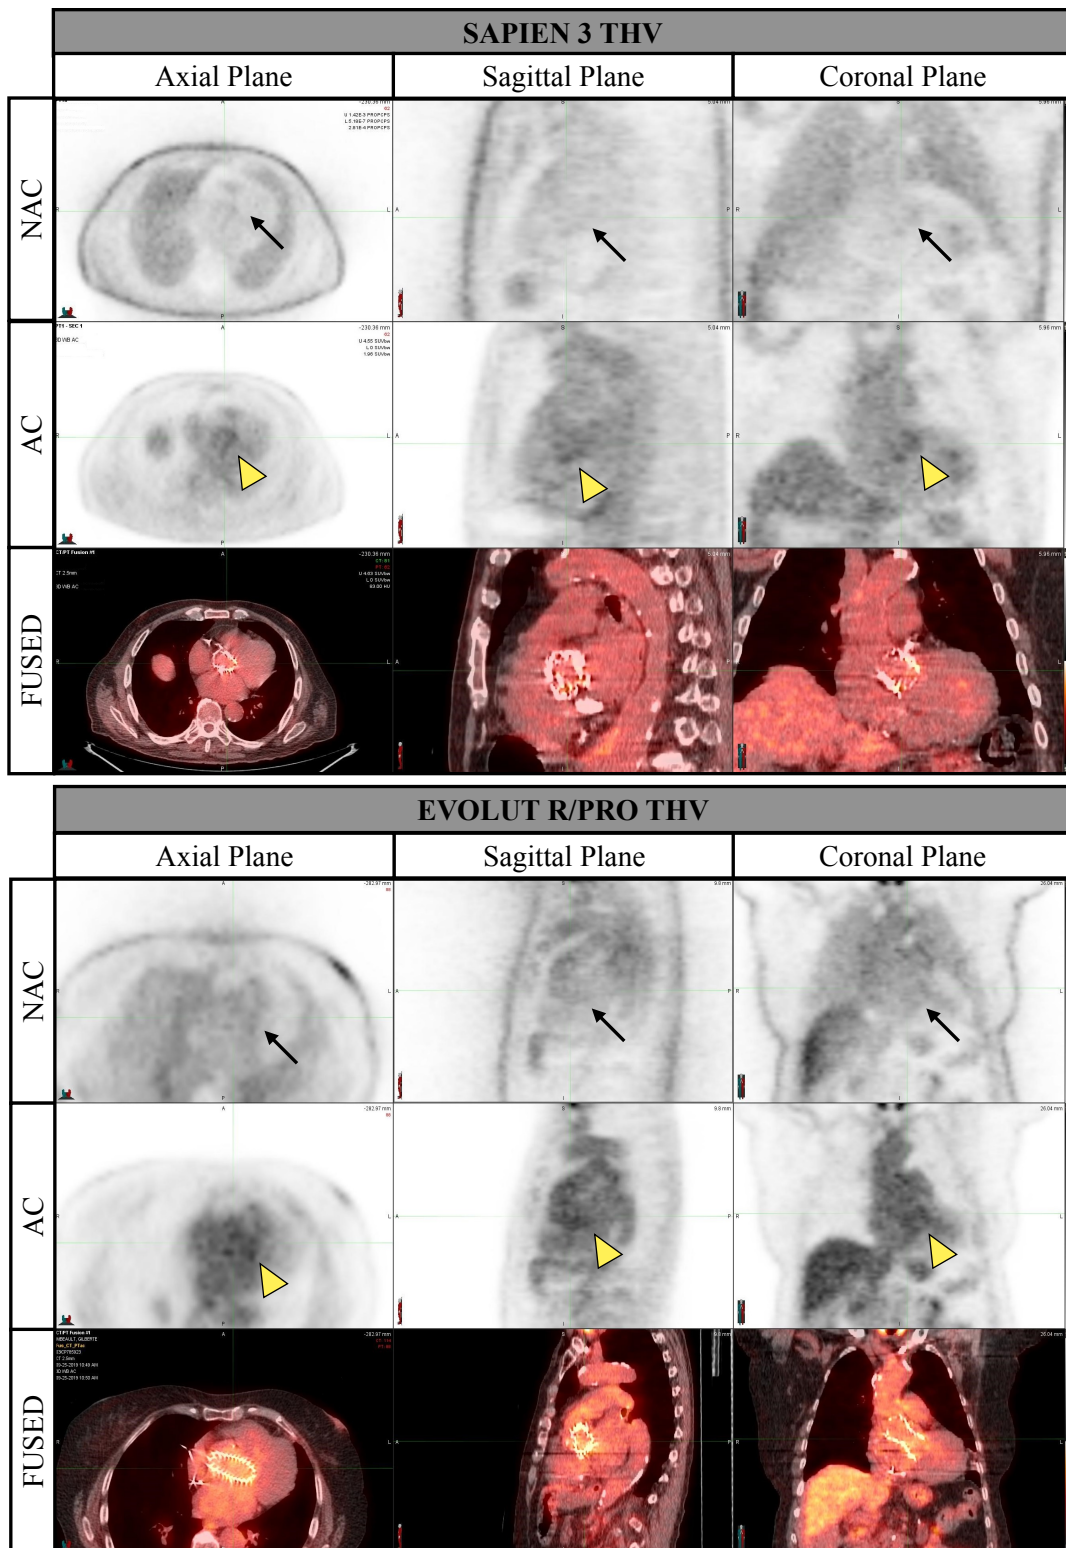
^{18}F -Fluorodeoxyglucose (^{18}F -FDG) uptake in patients with noninfected transcatheter aortic valves.
